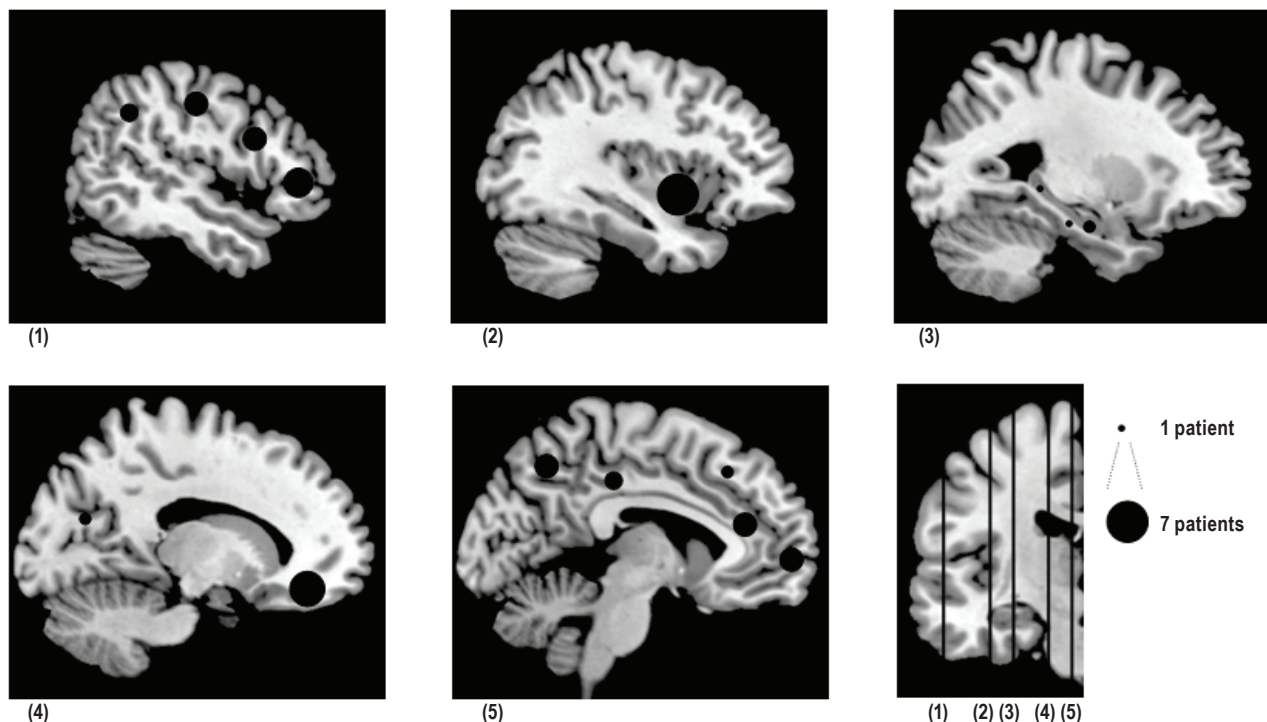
Electrode locations on sagittal T1 MRI slices. Black-filled circles represent electrodes locations on sagittal T1 MRI slices. Topography of the sagittal sections is shown on the bottom right coronal slice, from (1) lateral to (5) medial. For each anatomical location, size is proportional to the number (1 to 7) of the patients explored. Slice (1): posterior lateral frontal cortex (precentral gyrus, precentral sulcus): n = 4; middle lateral frontal cortex (F1 to F3): n = 4; anterior lateral frontal cortex (pole): n = 5; lateral parietal cortex: n = 3. Slice (2): anterior insular cortex: n = 7. Slice (3): anterior hippocampus: n = 2; posterior hippocampus: n = 1; entorhinal cortex: n = 1. Slice (4): orbitofrontal cortex: n = 6; occipital cortex: n = 2. Slice (5): anterior cingulate gyrus: n = 4; posterior cingulate gyrus: n = 3; medial parietal cortex: n = 4; anterior medial frontal cortex: n = 4; middle medial frontal cortex: n = 2.
